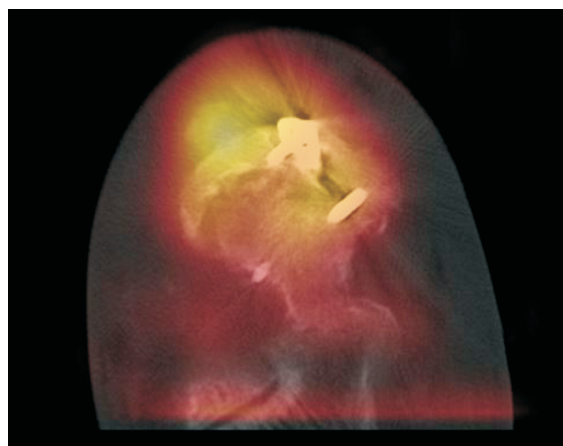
SPECT-CT imaging showing increased signaling of the distal screw utilized in locking plate for talonavicular joint fusion site.
